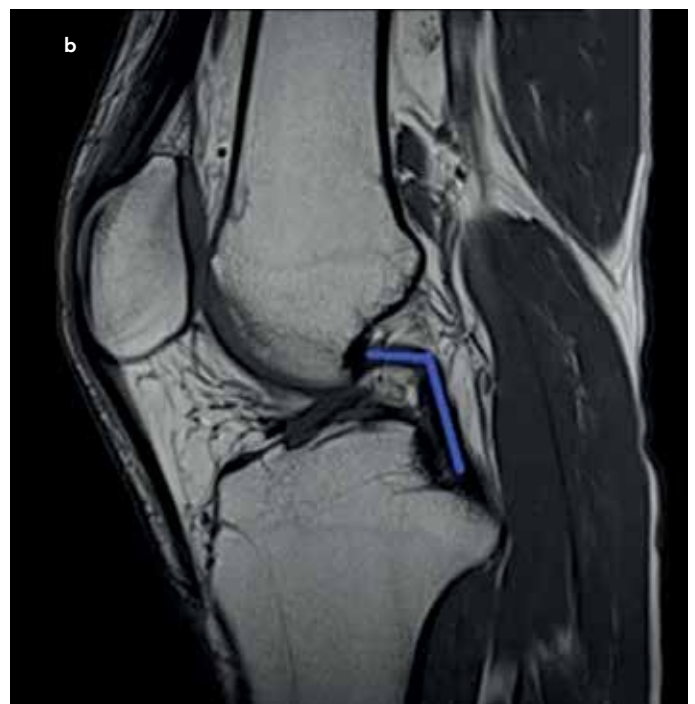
a, b. Sagittal proton-density MRI image of the knee: The amount between two longitudinal lines shows the anterior tibial translocation. (a) Sagittal T1 MRI image of the knee: The angle between the two blue lines shows the PCL buckling (b).
